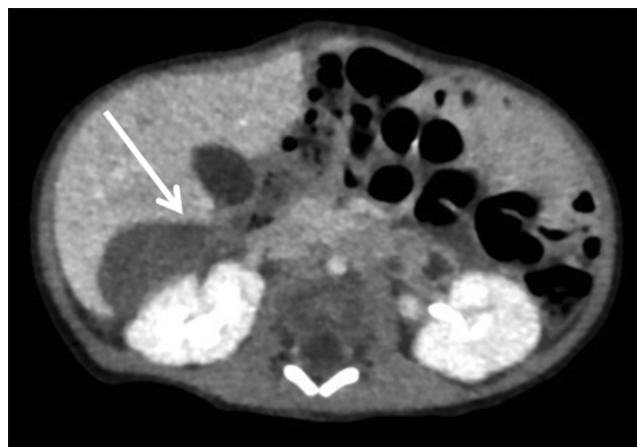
CT on Day 10 shows a 3.0 cm × 1.6 cm × 1.5 cm low-density lesion below the right hepatic lobe.
